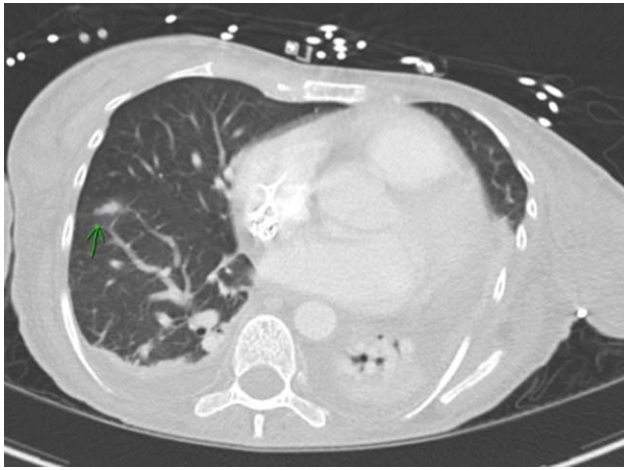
CT scan of the chest showing extramedullary involvement in a patient with WM with a lung mass and pleural effusion.
